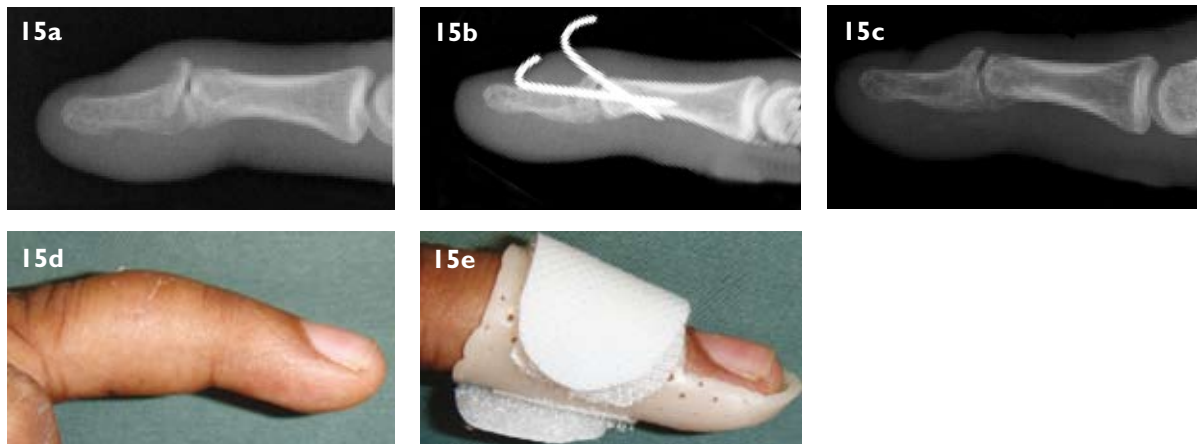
Mallet finger injuries can involve a bony element, or be purely ligamentous. Radiograph images show (a) a bony mallet finger with displacement of the avulsed intra-articular fragment dorsally, (b) intra-focal k-wires used to reduce and maintain the bone and tendon and (c) the results six weeks postoperation. Patients will usually have a slight extension lag of about 10° and a residual stiffness of the distal interphalangeal joint. (d, e) Mallet fingers that do not require fixation are splinted for a total of six weeks in a mallet splint.
